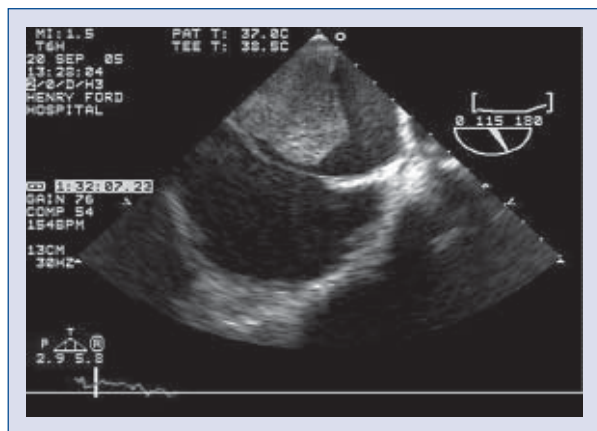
Transthoracic echocardiogram short axis aortic valve level of a study patient showing left atrial appendage (LAA) on the right side of screen with LAA thrombus from a study patient.
